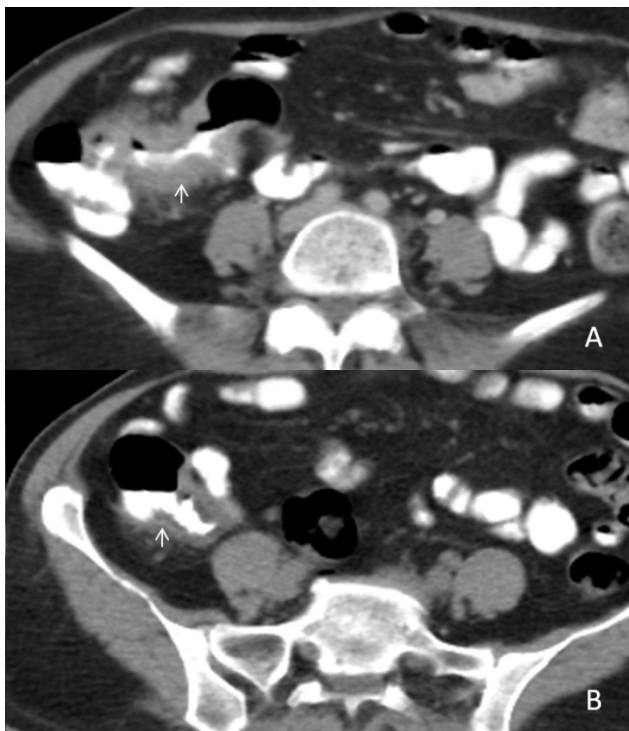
(A,B) A 25 years old lean and thin female presented with disturbed bowel habits and pain abdomen with on & off fever from last few months. A contrast-enhanced computed tomography scan in the axial plane (A & B) demonstrate thickening of the terminal ileum, ileo-caecal junction and caecum, causing lumen obliteration with surrounding mesenteric fat stranding (white arrow). After colonoscopy guided biopsy, it was proven to be intestinal tuberculosis. The patient had a standard four-drug regimen of ATT for six months, and after that, she was symptoms free.
